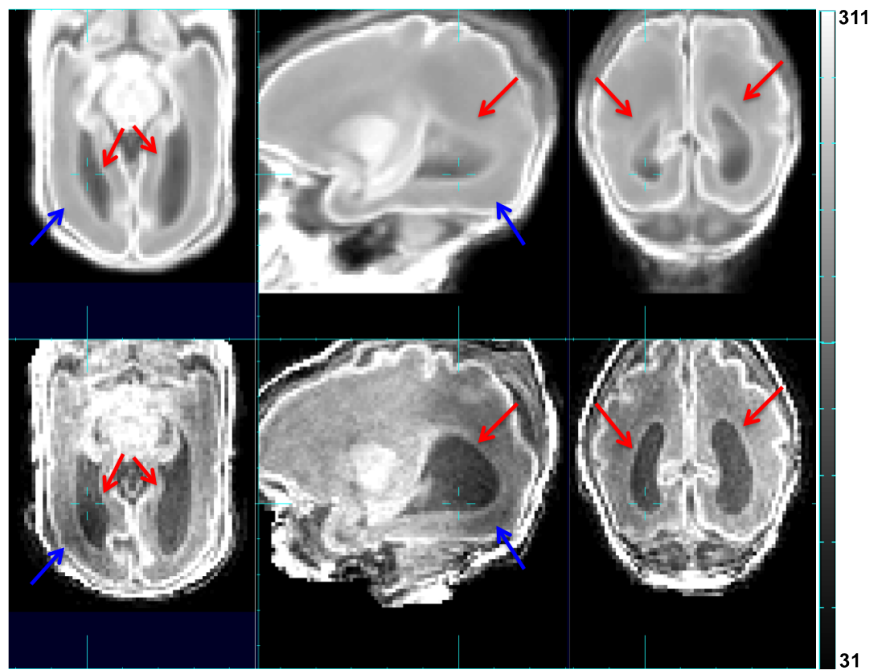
Comparison between the age-specific average image warped into subject space (upper row) and the subject MR image (lower row). Red arrow: difference in ventricle size and shape. Blue arrow: abnormal white matter intensity.
